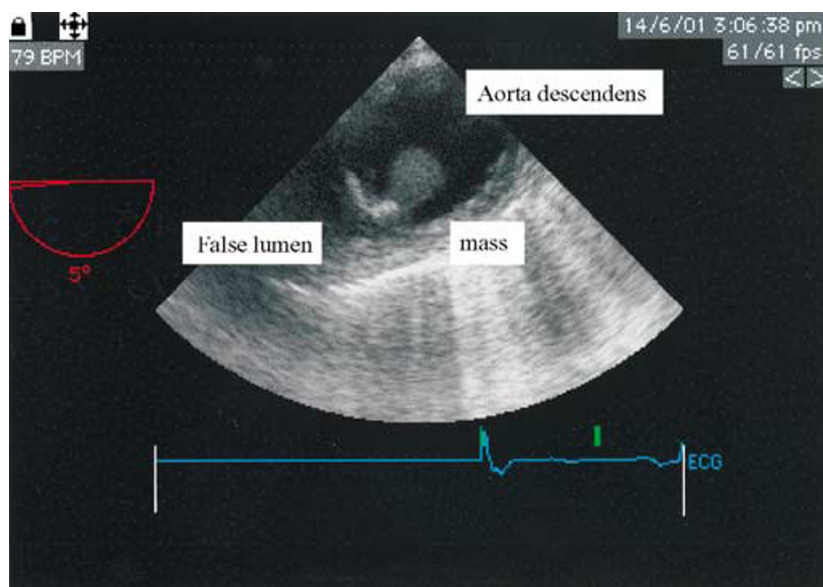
Transesophageal ultrasound. Transesophageal transversal image of the descending aorta showing a thickened intimal flap due to dissection, the false lumen, and the round vegetation protruding into the real lumen.
